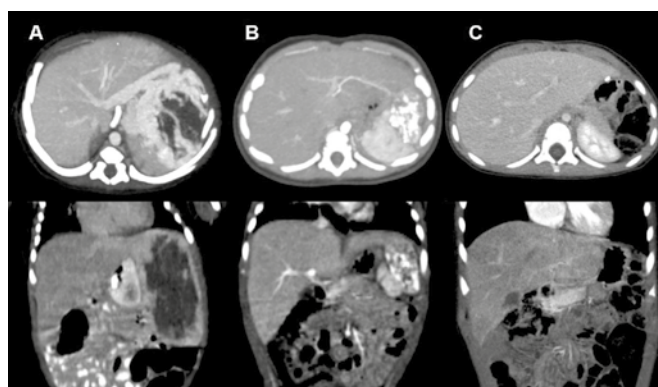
Female C, Kaposiform hemangioendothelioma. CT scans of a series of studies (axial and coronal) A. Initial scan shows massive hypervascular tumor in the left lobe of the liver, associated with the branches of the portal vein. B. After neoadjuvant chemotherapy, the volume decreased significantly, tumor partially calcified. C. After radical resection of the tumor, restoration of the shape of the liver.
